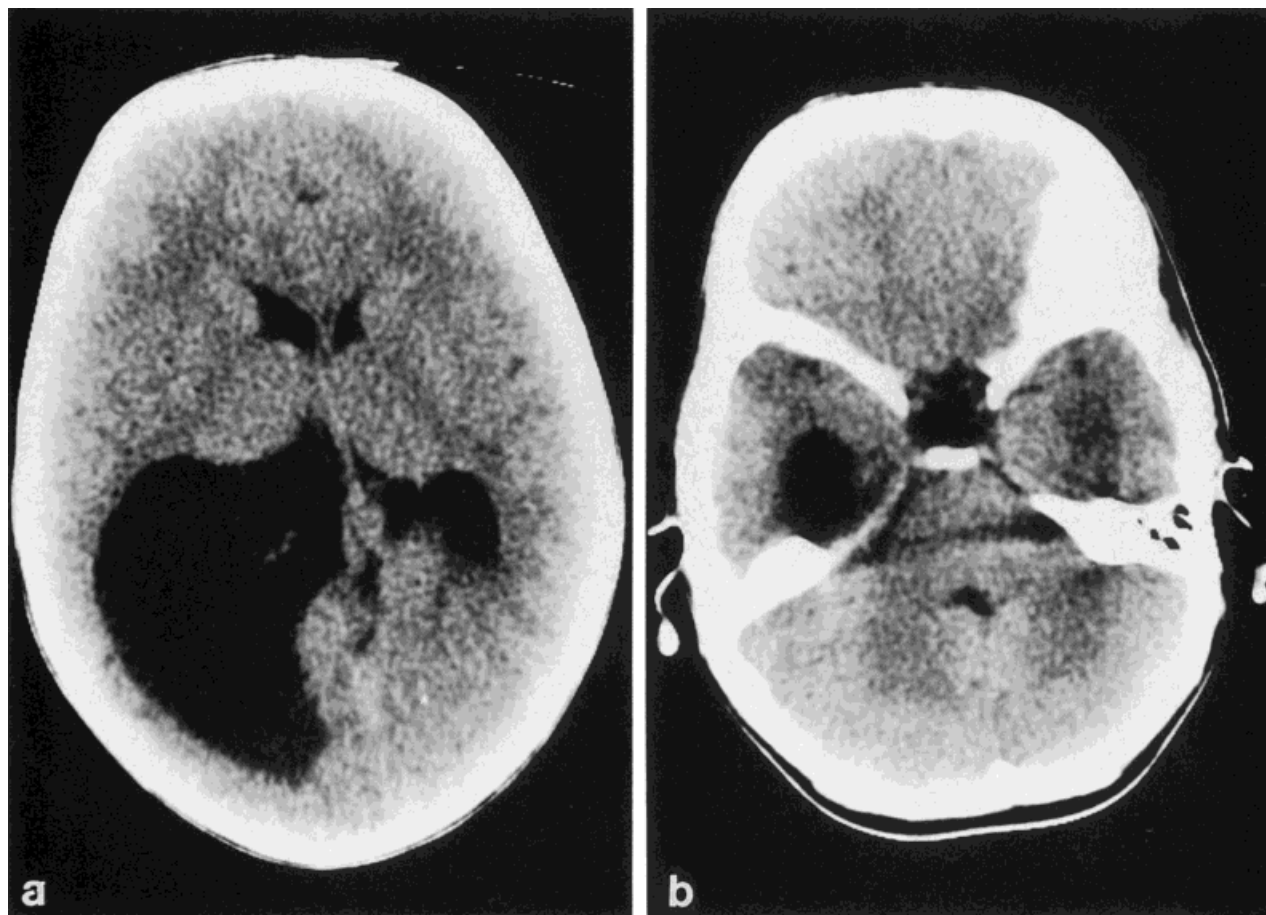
a: Axial CT brain scans of S.G. Note marked asymmetry and unilateral hydrocephalus. Marked dilation of right occipital horn and mild dilation of left occipital and right frontal horns. Age 13 months. b: Right temporal horn dilatation and normal fourth ventricle. Age 13 months.
